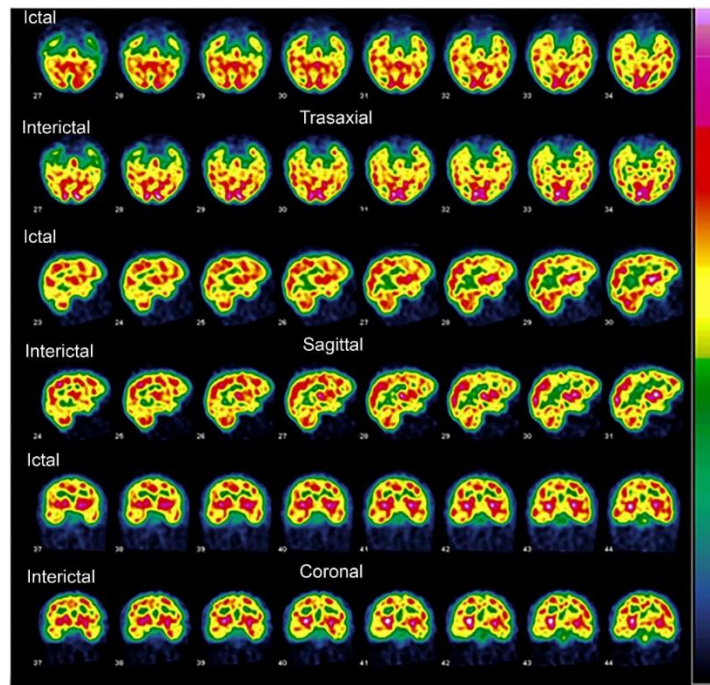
Ictal (EARLY) – Interictal (LATE) French color scale, axial, sagittal, coronal Tc-99m ECD SPECT images with the temporal plane
